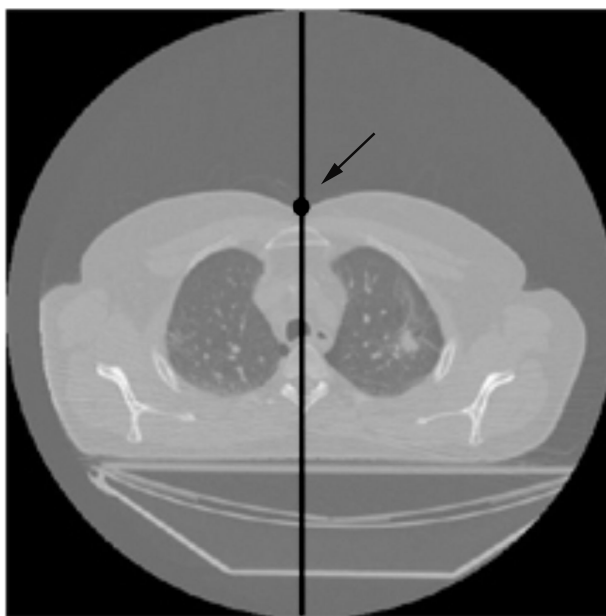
An axial CT image of the thorax; highlighted is the profile line and chest position.
